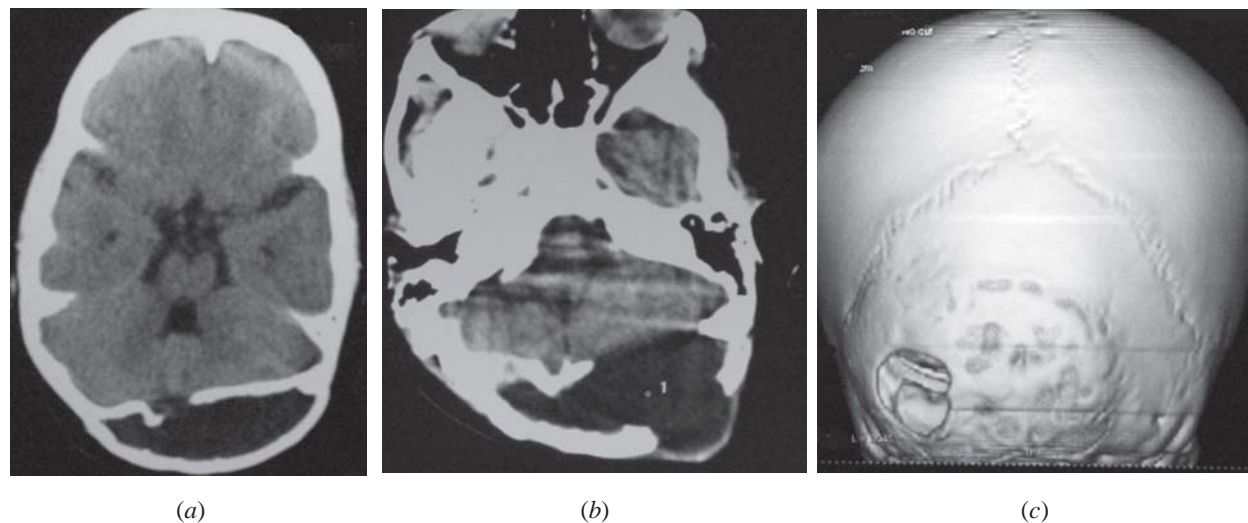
(a) Plain CT head, axial section demonstrating a defect in the inner table of the occipital bone with associated hydrocephalus. The outer table is seen to be bulging outwards. (b) Plain CT head, axial section showing the subcutaneous bulge through the burr hole site. (c) 3D reconstruction CT of the occipital region demonstrating the defect in the inner and outer table of the occipital bone.
